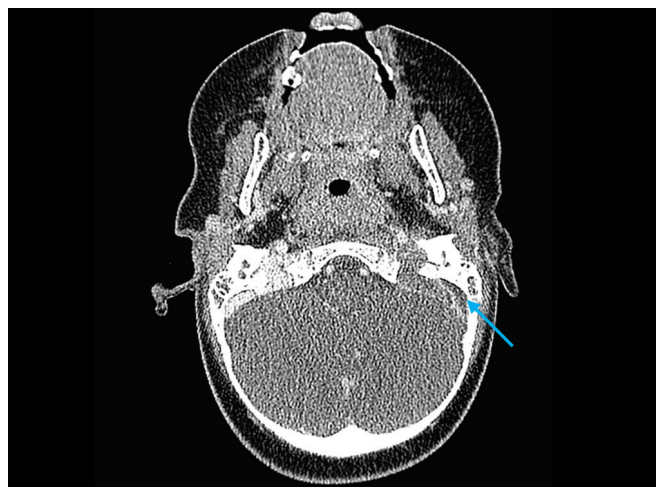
Axial CT scan showing epidural abscess (arrow) adjacent to a thrombosed left sigmoid sinus.
